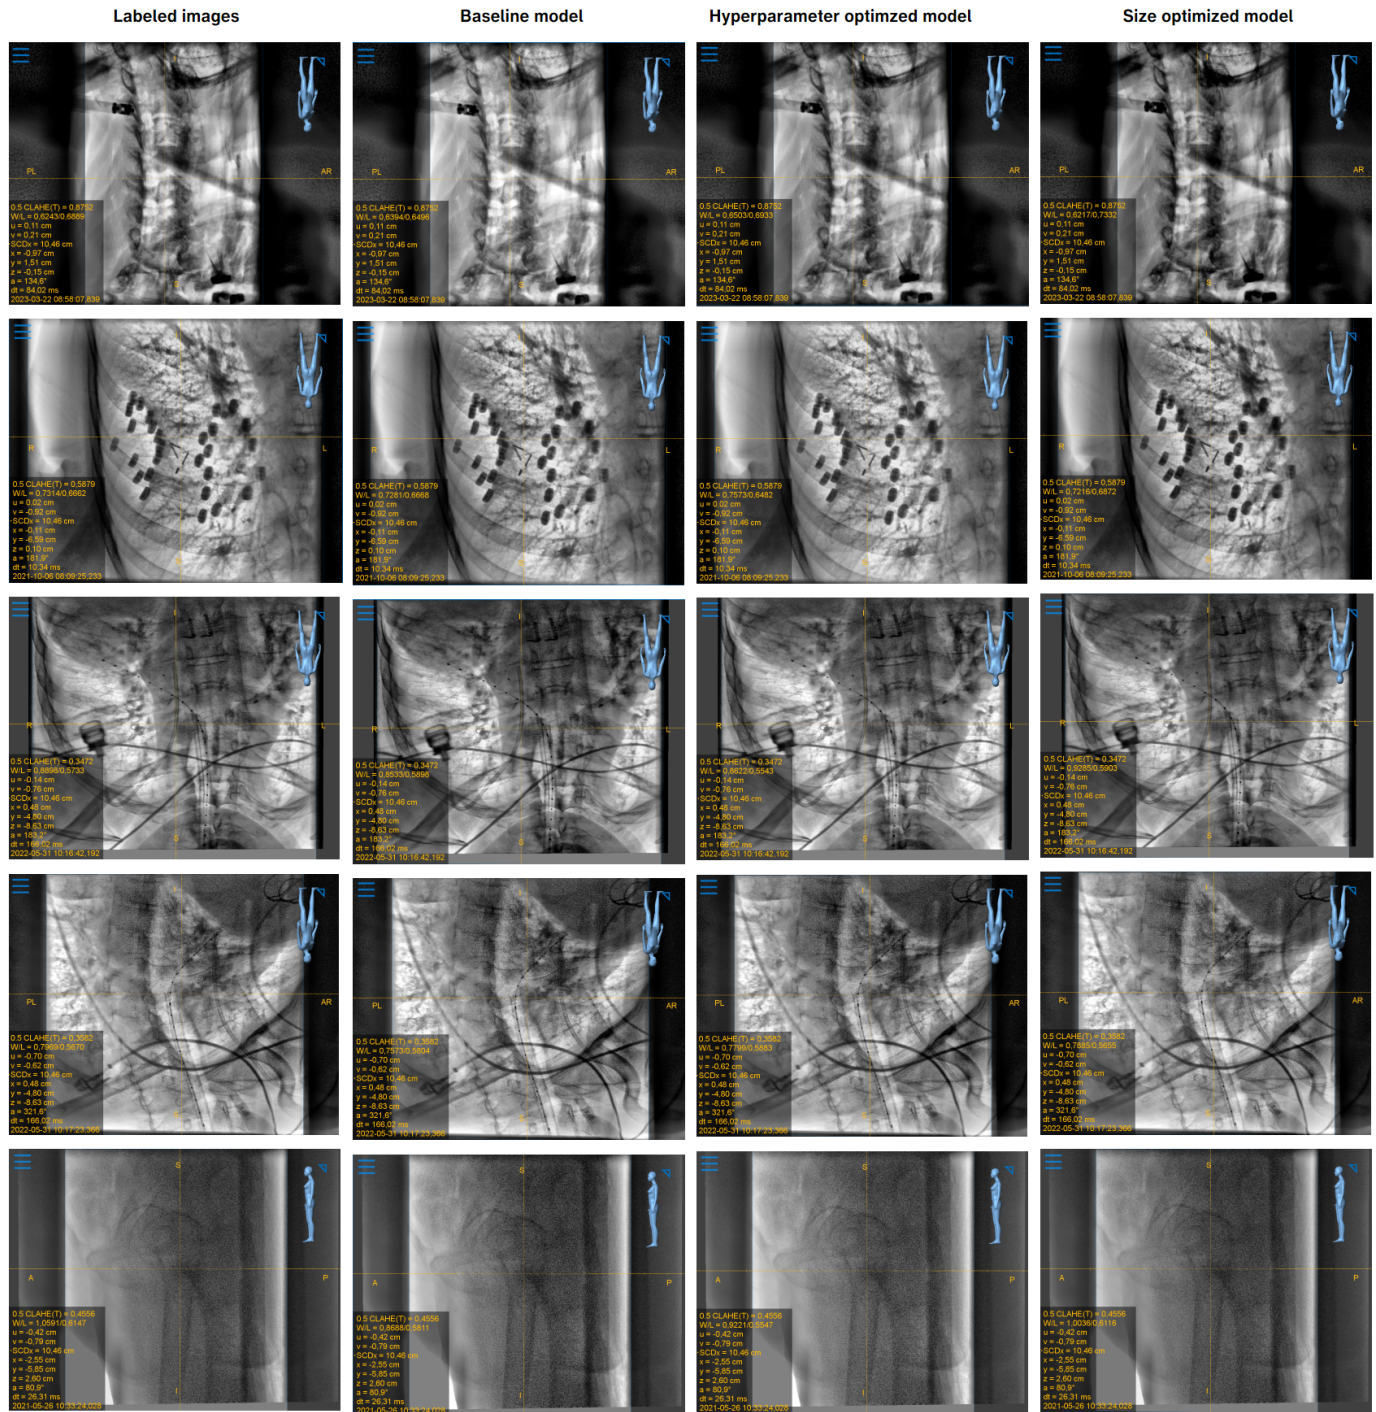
Example x-rays visualized with the label and the predicted window-leveling parameters. *Left column:* X-rays visualized with label values. *Left middle row:* X-rays visualized with parameters predicted by baseline model. *Right middle column:* X-rays visualized with parameters predicted by the model with optimized hyperparameters. *Right column:* X-rays visualized with parameters predicted by the model with optimized size.
